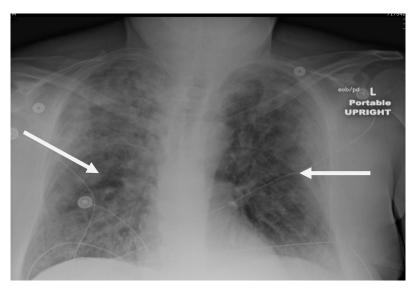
Chest x-ray shows diffuse airspace consolidation.
